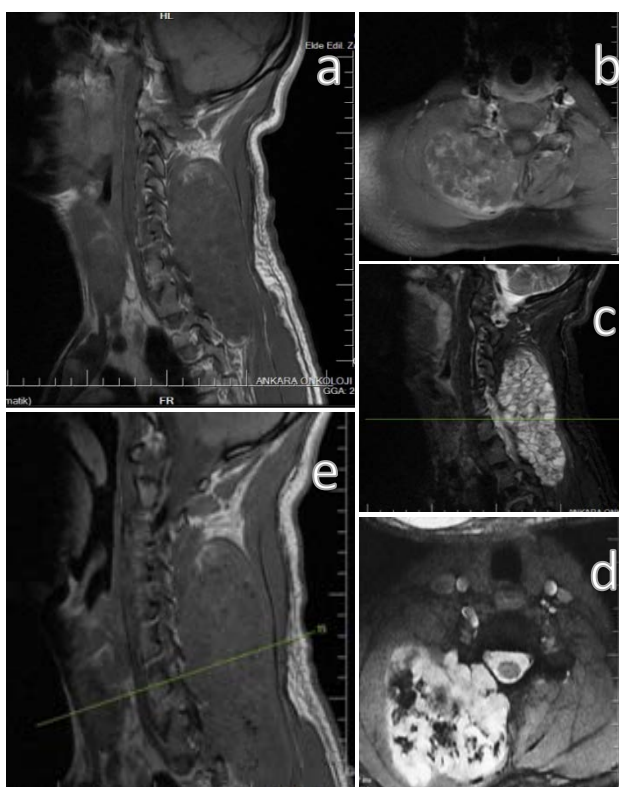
Preoperative MRI sections
